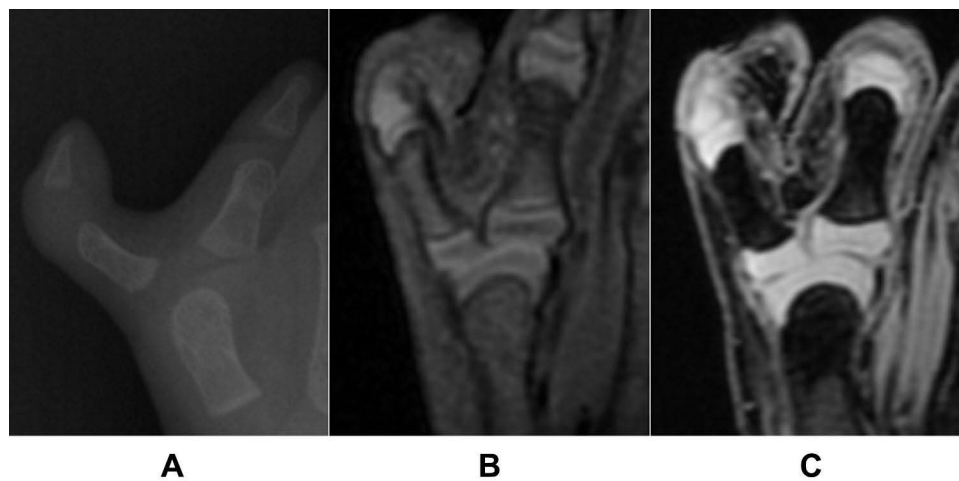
Different imaging techniques of a case with radial polydactyly at the MP joint level. (A) Plain radiograph (PA view); (B and C) Coronal MR images of FS PDW imaging (B) and FS 3D SPGR imaging (C). Note better delineation of chondral morphology and joint characteristics in the duplicated digits when image obtained at FS 3D SPGR imaging.
